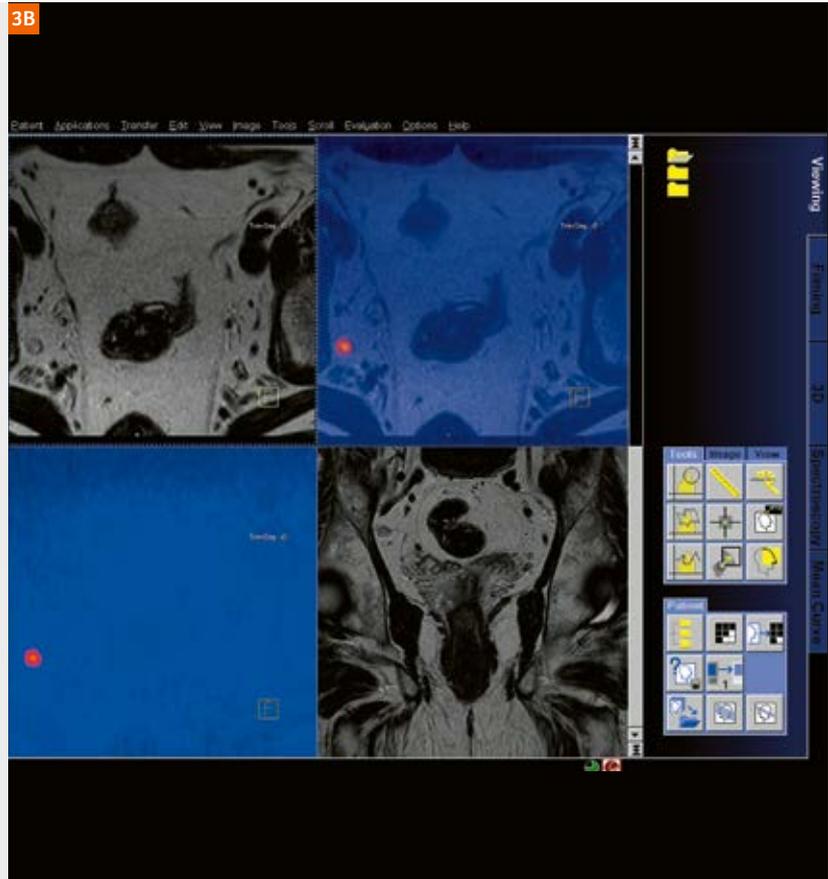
Nodal evaluation with diffusion-weighted MRI
